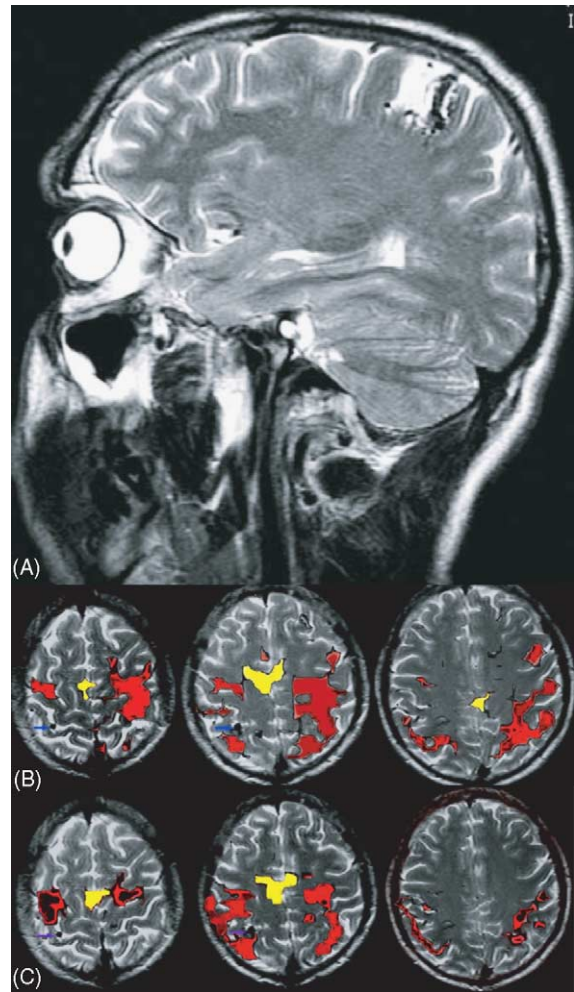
(A) AVM is seen located in the postcentral gyrus at the right rolandic level on T2-weighted sagittal image. (B) and (C) Cortical activation areas corresponding with the finger tapping of the right (B) and left (C) hands on three axial consecutive images. Sensorimotor areas of the right hand are located in both cerebral hemispheres, but considerably in the left cerebral hemisphere. And sensorimotor areas of the left hand are located in both hemispheres, but considerably in the right cerebral hemisphere (red colored areas). Sensorimotor areas are laterally displaced minimally on the lesion side. Activation areas belonging to supplementary area are seen in the mid-line location (yellow colored areas).
